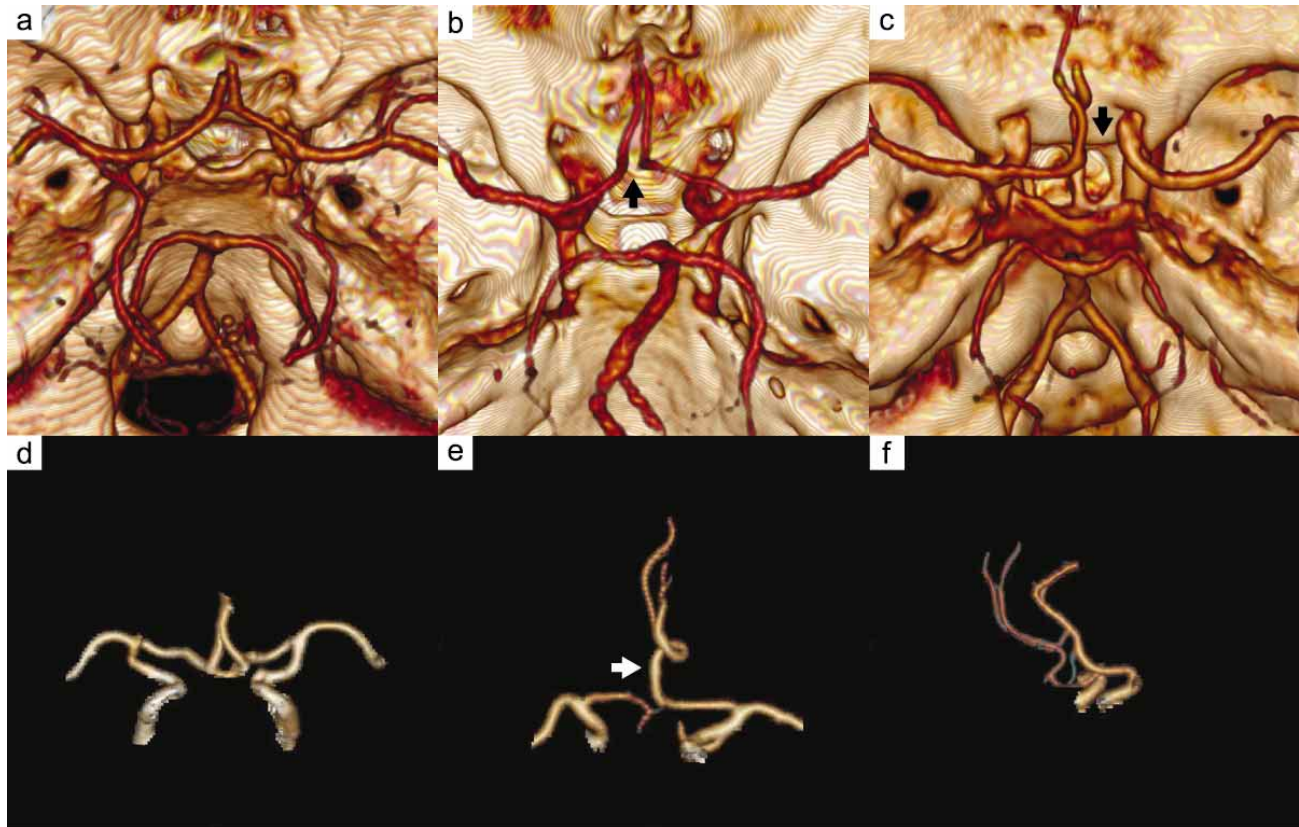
Images obtained by computed tomography with 3D reconstruction in different patients that show anatomical variants found in the circle of Willis (arrows). A) and D) "Typical" variant of the anterior cerebral artery–anterior communicating artery; B) Absence of the AComA; C) Absence of the right precommunicating A1 segment of the anterior cerebral artery; E) Azygos artery, F) triple variant of the ACA.
